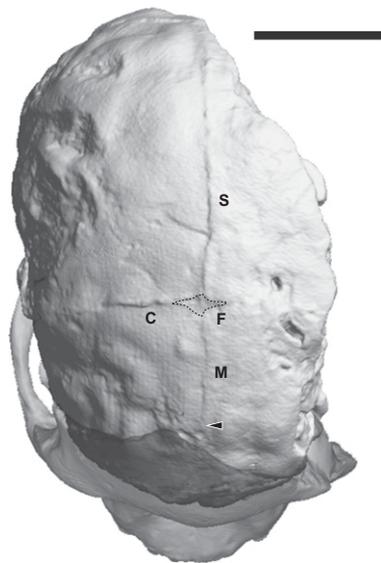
CT-based superior view of the Taung natural endocast (solid) and face (transparent). Note imprints of sagittal (S, interparietal), coronal (C), and metopic (M) sutures (arrowhead denotes endpoint), and fontanelle (F, area delimited by dashed line). (Scale bar, 30 mm.)
